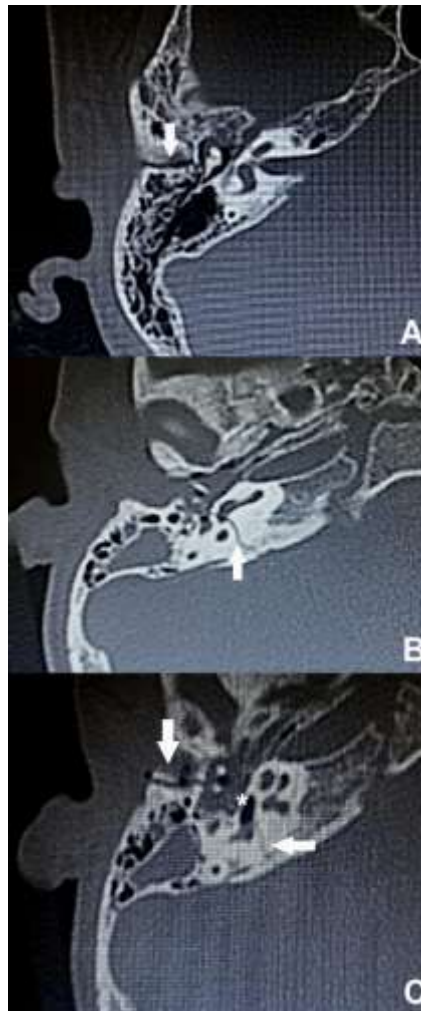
Axial computed tomography of the right ear of different patients. A = longitudinal fracture. B = Transverse fracture. C = Longitudinal (vertical arrow), and transverse fracture (horizontal arrow) with pneumolabyrinth (asterisk).
